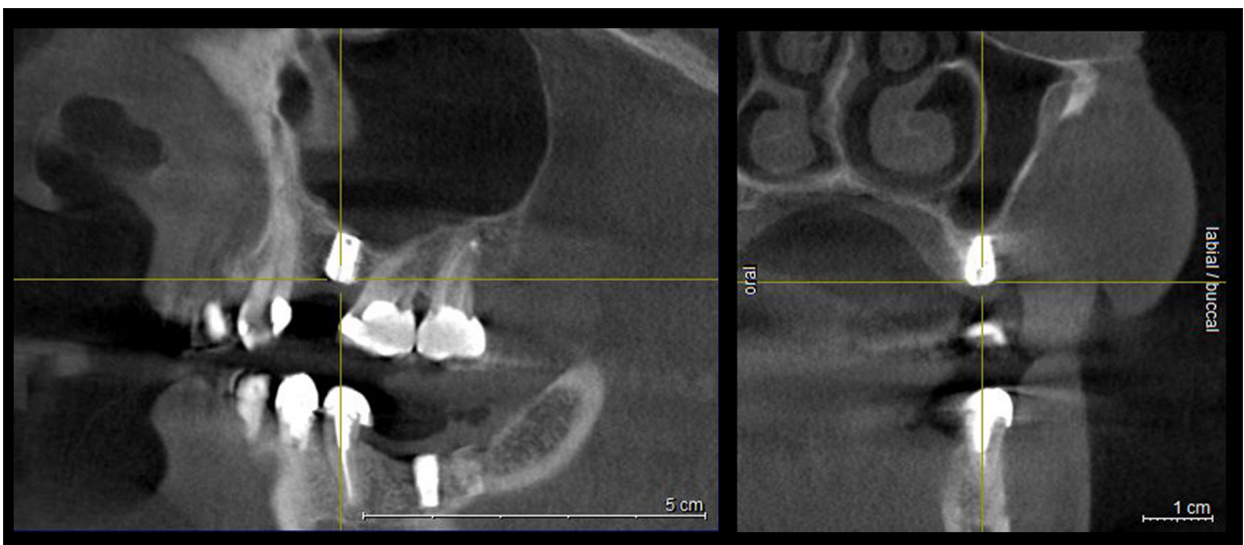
RVG, CBCT, OsseoSpeed™ short implant, T0, Initial.
